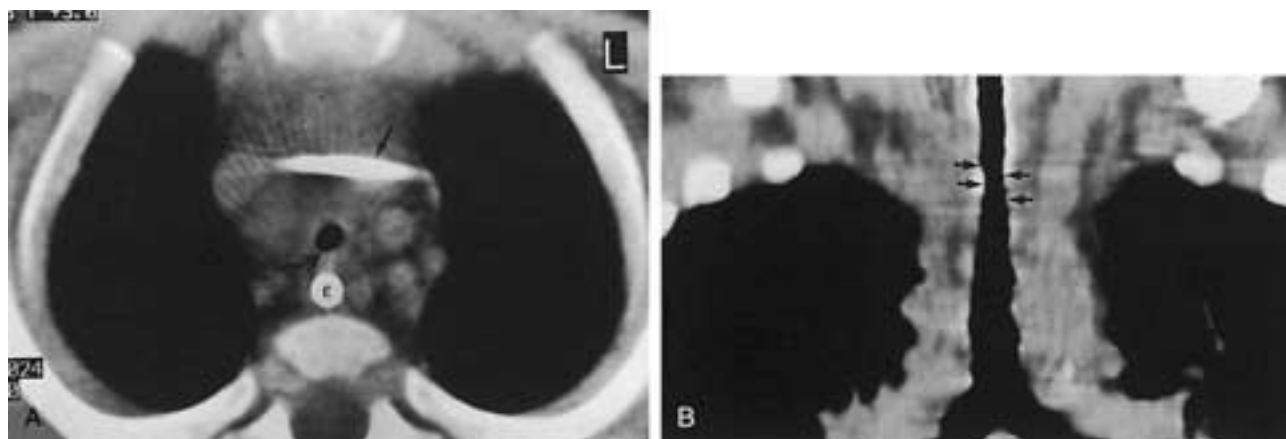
Congenital tracheal stenosis in a 2½-year-old boy with stridor. A, Axial spiral CT scan obtained immediately below the endotracheal tube shows a central venous line (*arrow*) and a nasogastric tube in the esophagus (*E*). The posterior membranous portion of the trachea is not flat but has a rounded contour (curved arrow). B, Two-dimensional coronal reformatted image shows the extent of the tracheal narrowing.
